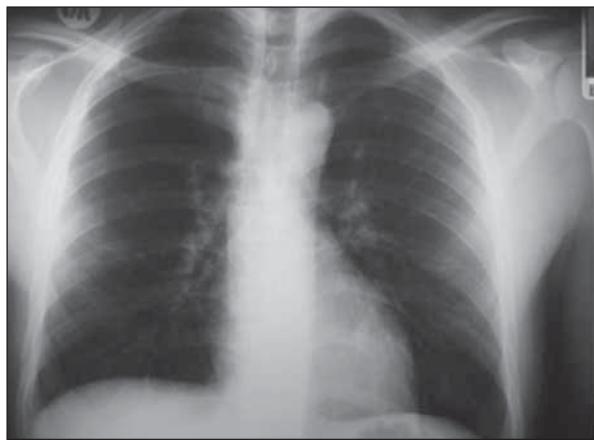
Chest x-ray one month after discharge
